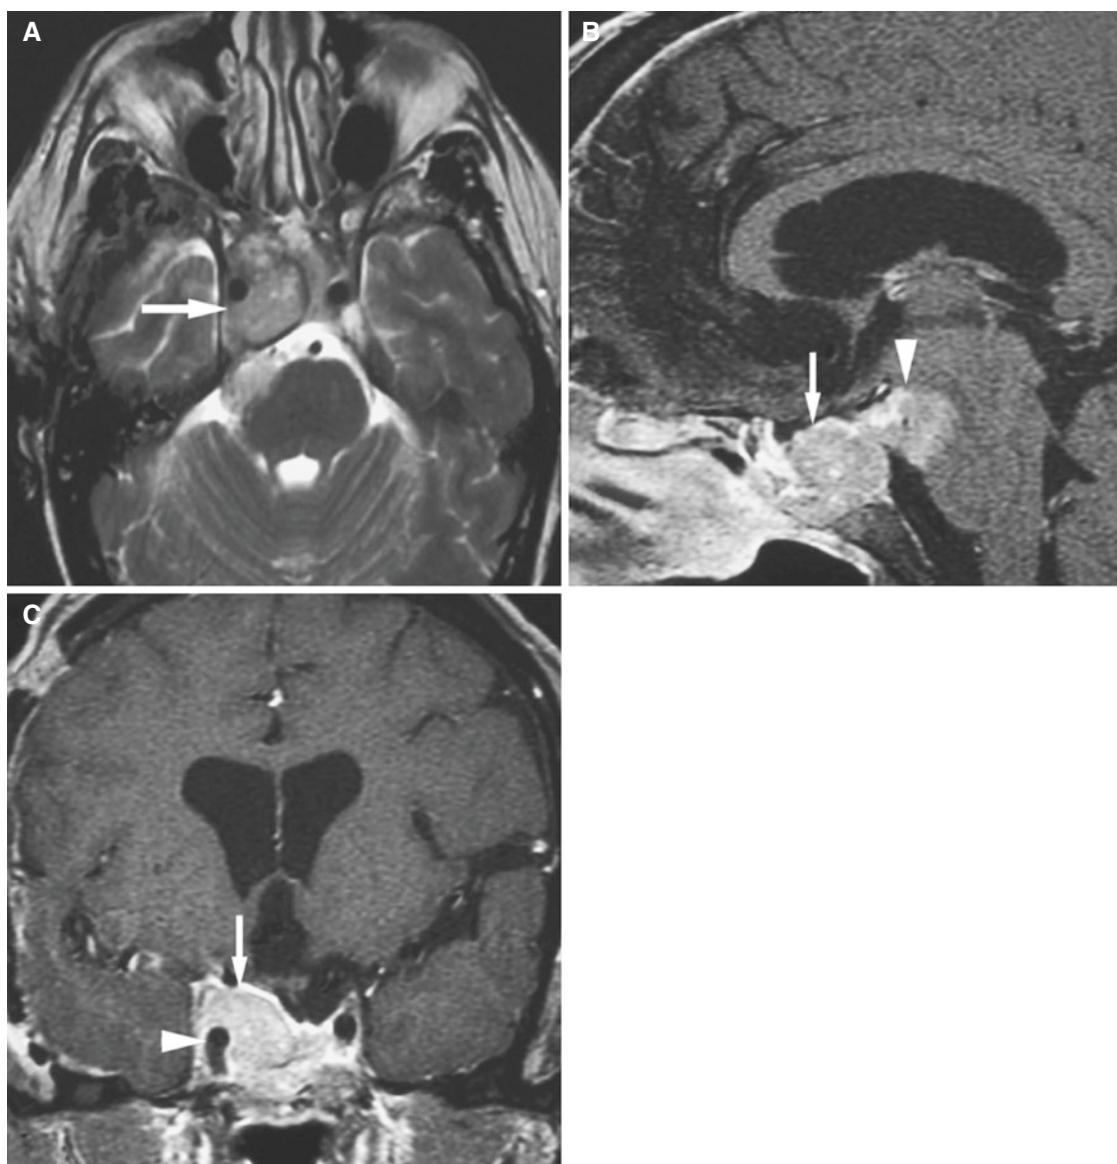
Pituitary macroadenoma; 53-year-old male with visual disturbance. (A) Axial T2-weighted MRI shows heterogeneous large mass in sella and right cavernous sinus (*arrow*). Mass extends posteriorly into brain stem causing compression of brain stem. (B) Sagittal T1-weighted post-Gd MRI shows mass expanding sella and extending
